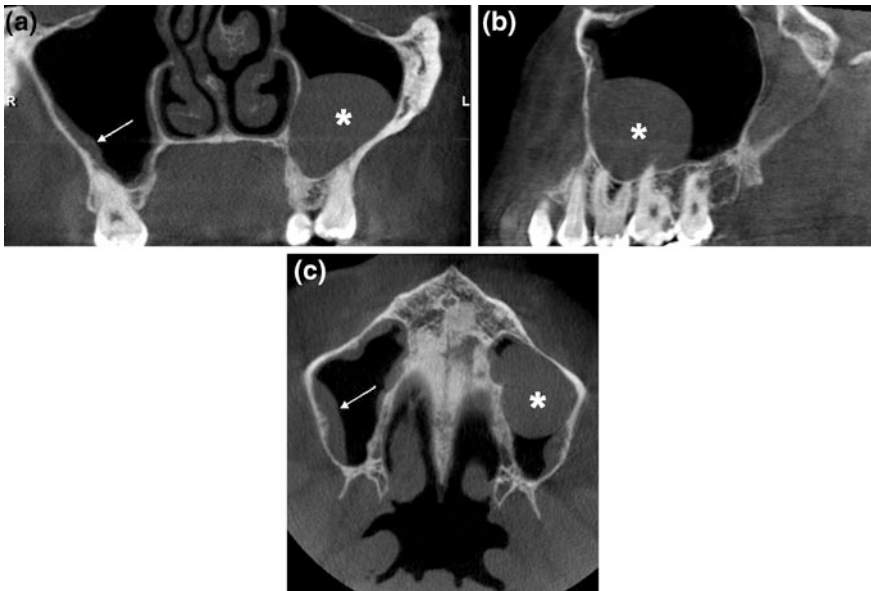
CBCT coronal (a), sagittal (b) and axial (c) scans of maxillary sinuses: mucosal thickening on the *left* sinus floor that appears like an antral mucosal pseudocysts, also called mucocèles (*asterisk*); mucosal thickening on the *right* side (*arrow*)
